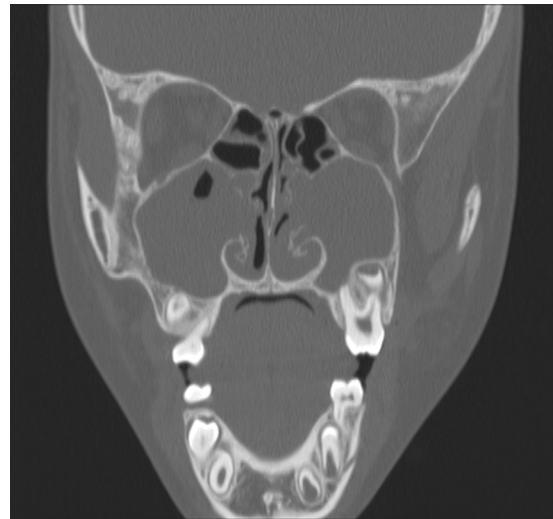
In a 9-year-old male patient, coronal CT scans show a soft tissue mass in bilateral maxillary sinus, extending to the nasopharynx.
